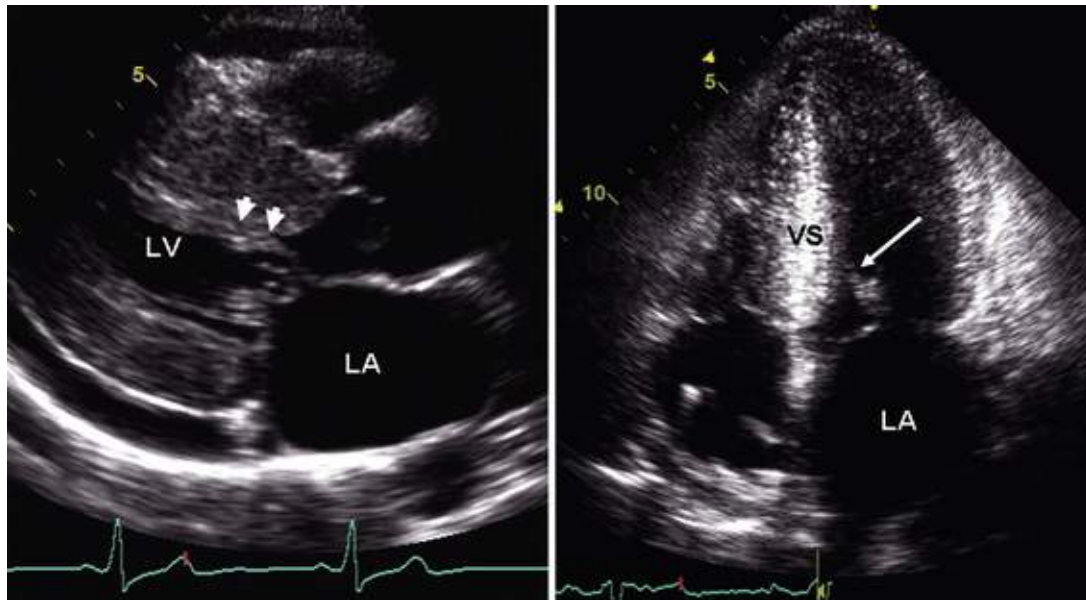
Hypertrophic cardiomyopathy. A parasternal long-axis view (left) shows markedly increased septal wall thickness and systolic anterior motion of the mitral valve (*arrows*), also visualized in the apical four-chamber view (right). Note the sigmoid, banana-shaped septum. LA, Left atrium; LV, left ventricle; VS, interventricular septum. (See Videos 14.17 and 14.18.)
